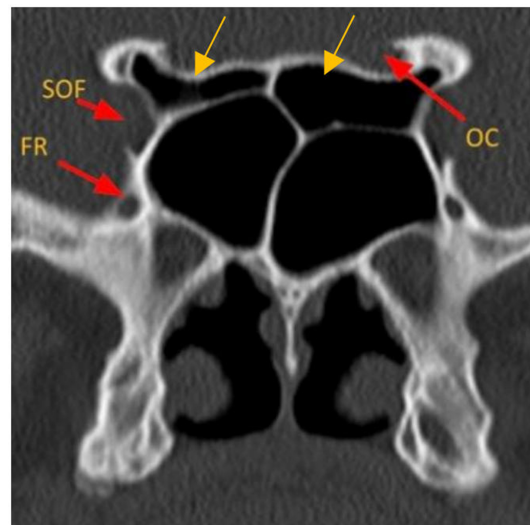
Coronal CT image of skull base foramina. SOF: Superior orbital fissure; FR: foramen rotundum; OC: optic canal. Onodi air cells (yellow arrows), anatomical variant. CT: Computed tomography.
